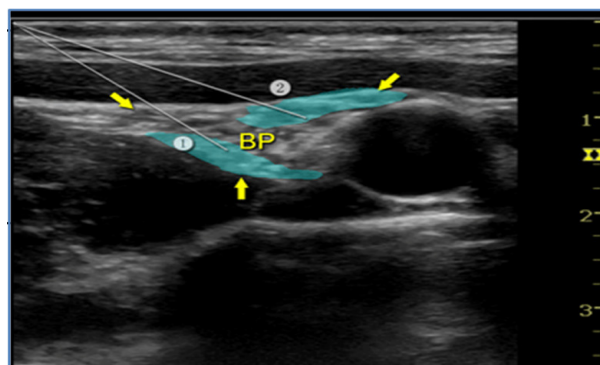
Ultrasound image of Brachial plexus showing two needle block positions⁹
